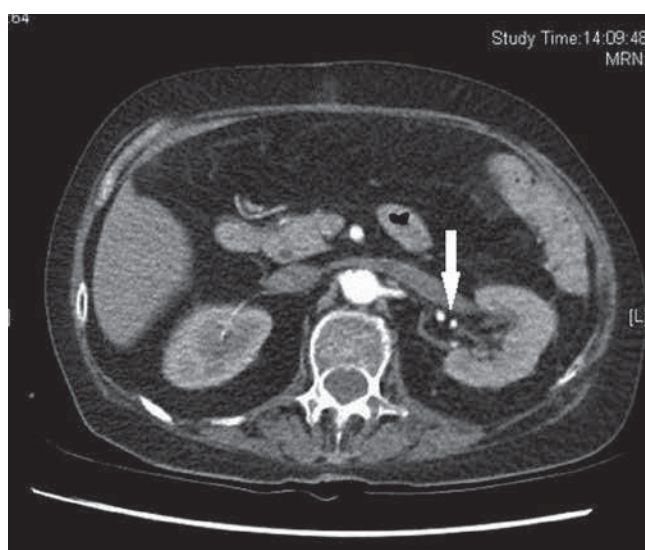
CT abdomen. Arrow shows left renal vein thrombus.
